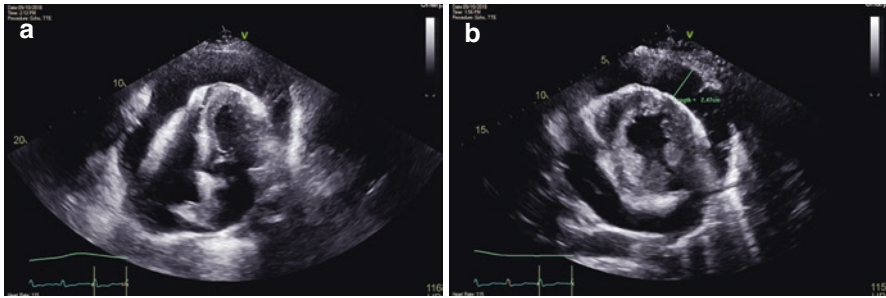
2D echocardiogram showing a large pericardial effusion in (a) apical four chamber and (b) short axis
